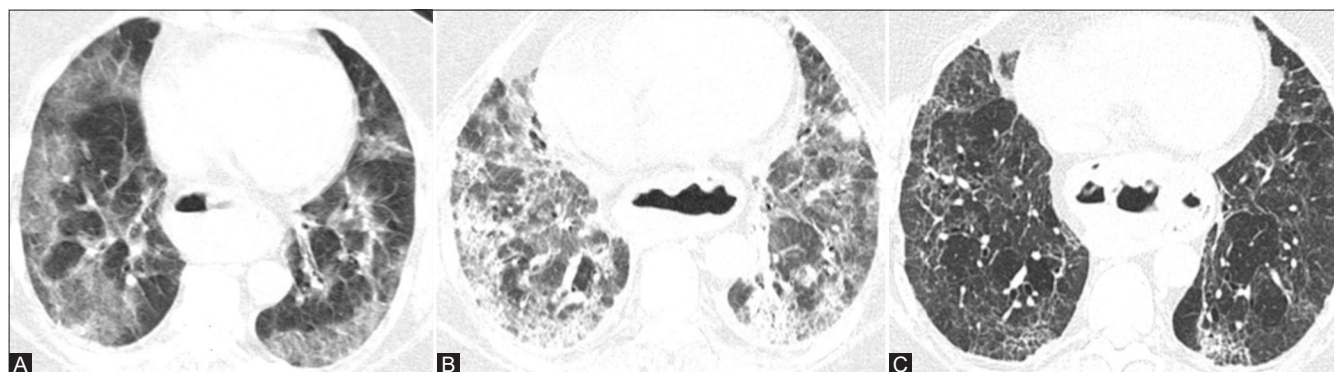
(A-C): HRCT (A) shows typical COVID19 pneumonia with subpleural distribution of ground glass densities. HRCT (B) after 30 days shows ground glass densities turning into extensive consolidation and reticular abnormalities HRCT (C) after 155 days shows considerable resolution
